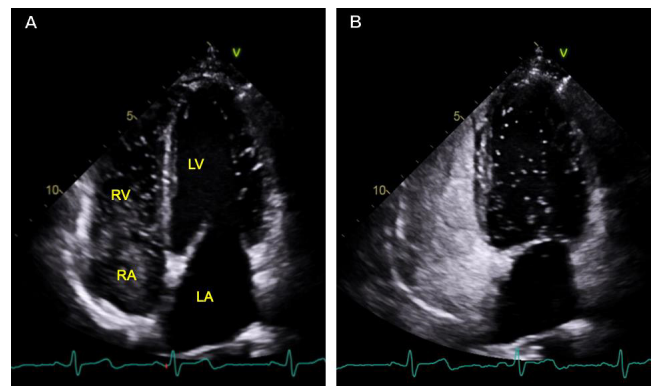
Trans-thoracic echocardiography bubble study revealing patent foramen ovale with right-to-left shunt. A) Apical 4-chamber view of heart immediately following intravenous injection of agitated saline. Microbubbles can be observed in the right atria and right ventricle. B) Apical 4-chamber view of heart several seconds after intravenous agitated saline injection. Microbubbles are visualised in left ventricle. Dense bubbles in right atria and ventricle cause opacification. RV: Right ventricle; RA: Right atrium; LV: Left ventricle; LA: Left atrium; V: Ventral.
